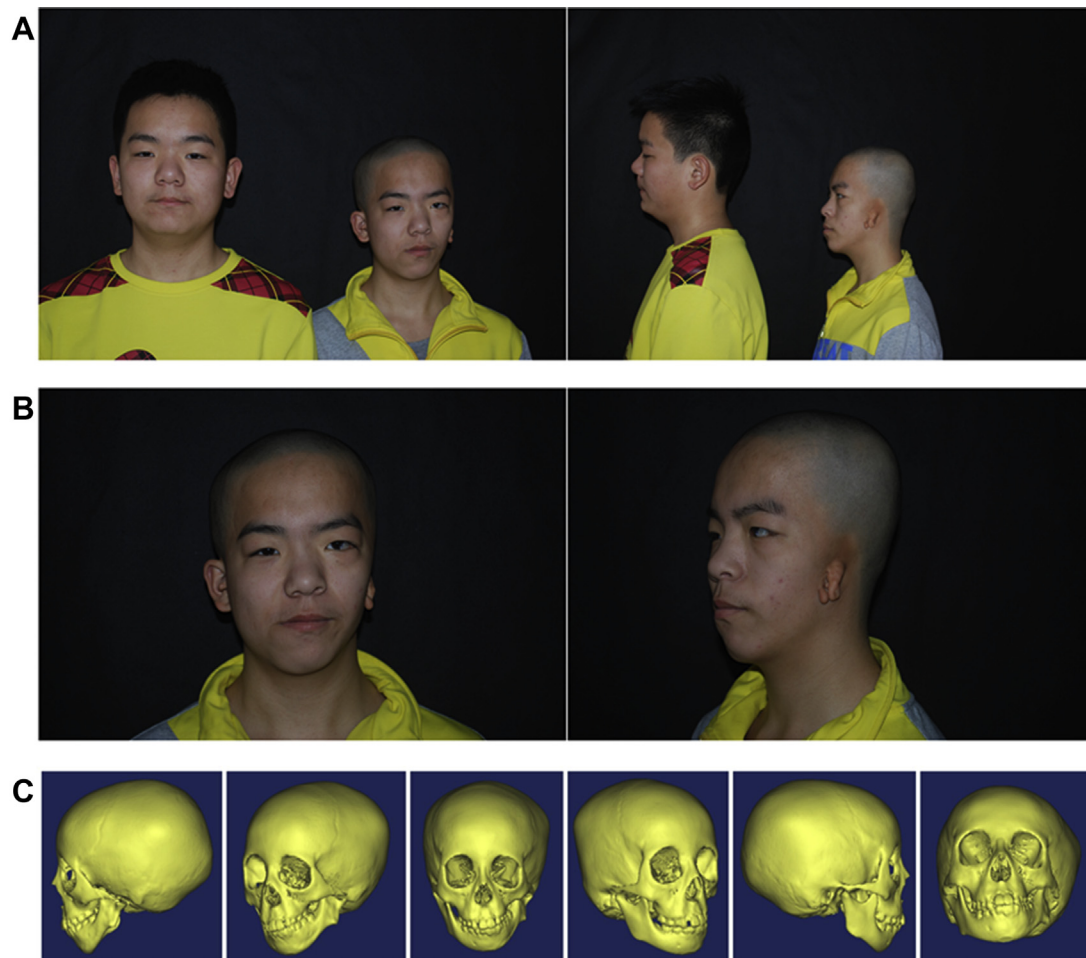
(A) Monozygotic twins discordant for hemifacial microsomia (HFM) described as Case 1. Left: the healthy twin. Right: the HFM patient. (B) Front view and left-side view of the HFM patient. (C) Three-dimensional computed tomography scan of the HFM patient. Left to right represents the left, left anterior oblique, front, right anterior oblique, right, and upward view, respectively.
